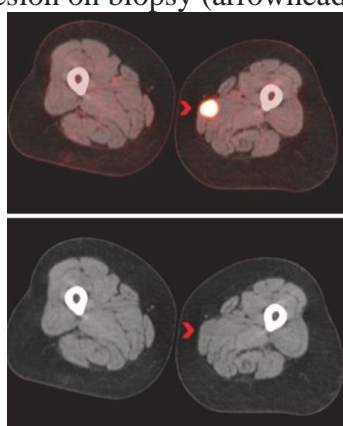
PET-CT axial view of left lower extremity showing slightly hypodense lesion and proven as a metastatic lesion on biopsy (arrowhead) (Moerlein *et al.*, 2020).
